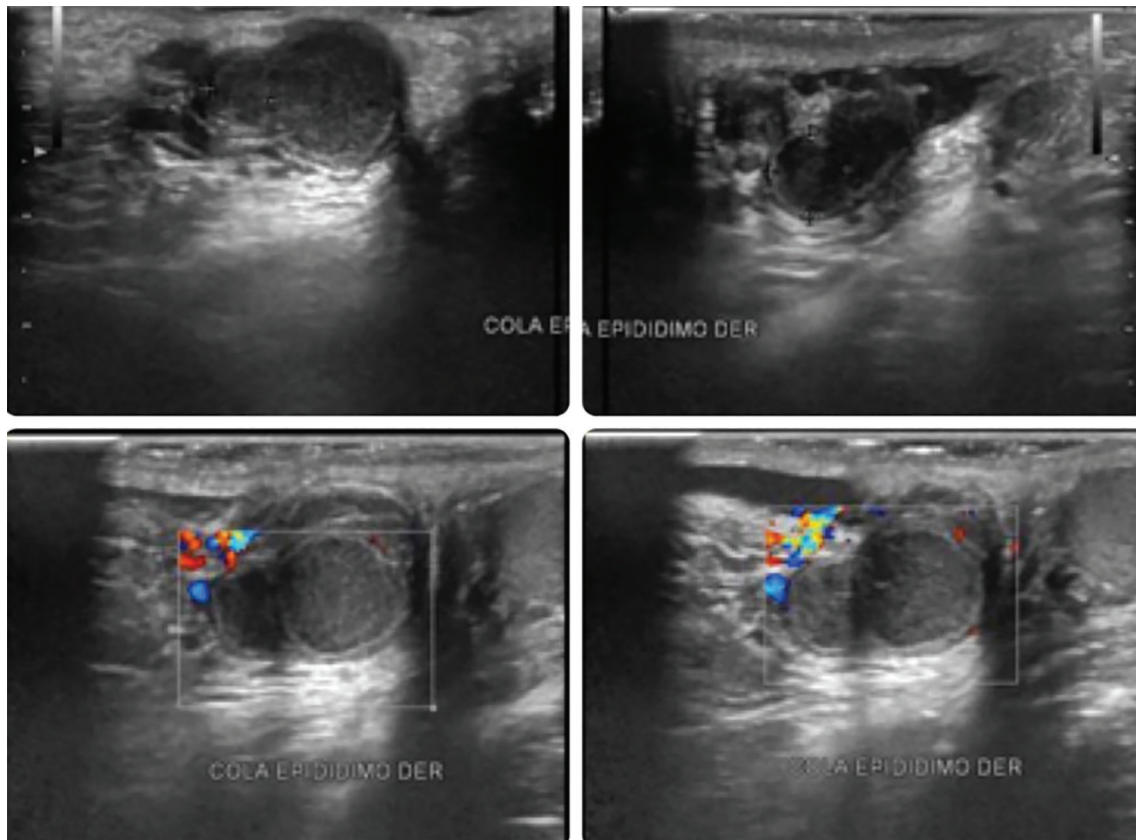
Tumor of the epididymis due to disseminated coccidioidomycosis. Color flow doppler testicular ultrasonography revealed the presence of two nodular masses in the tail of the right epididymis with increased vascular Flow.
